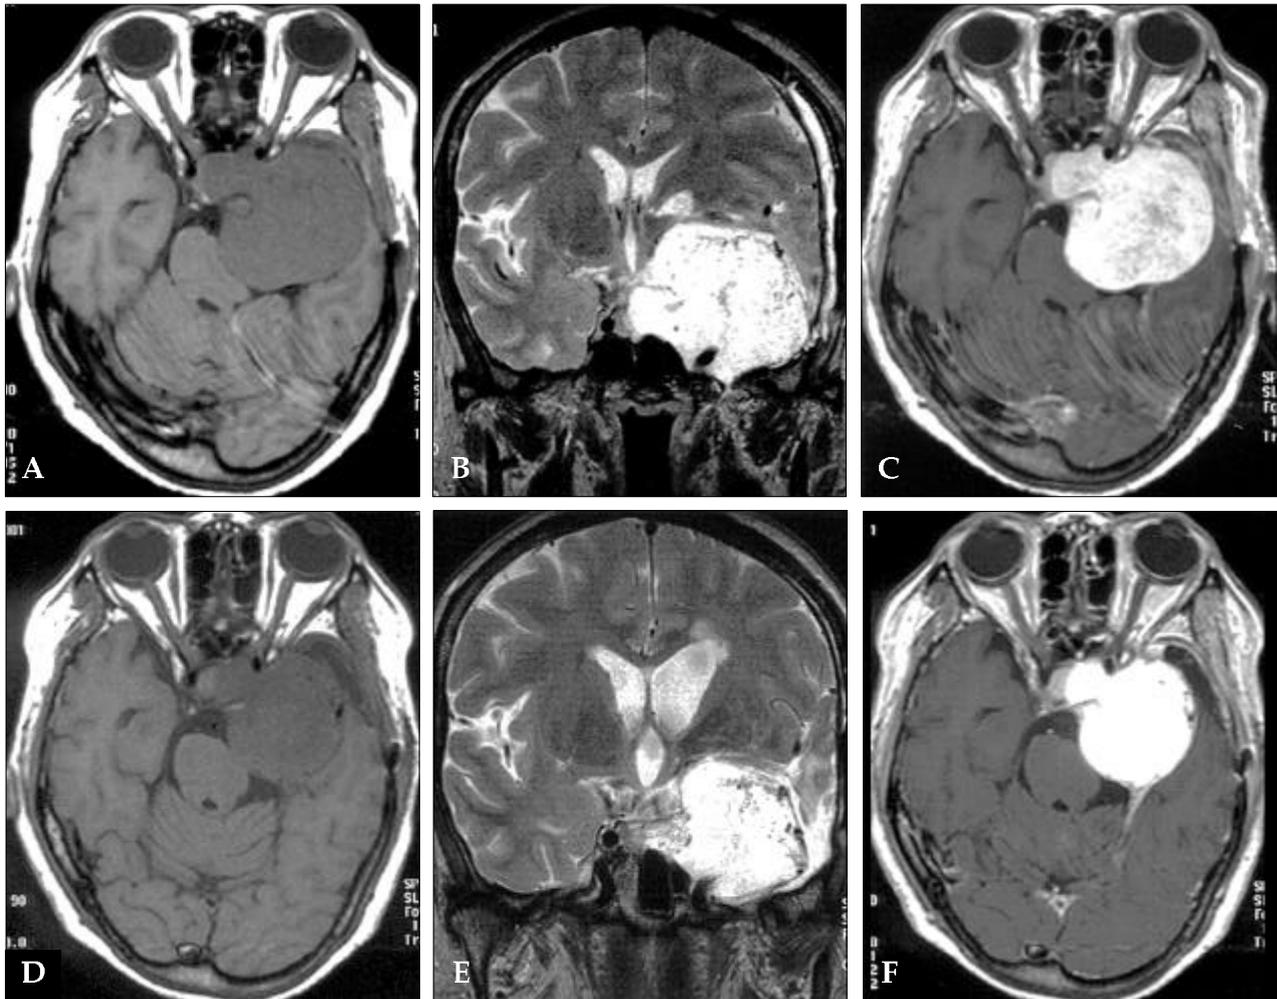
Before radiotherapy, a large cavernous hemangioma is noted in the left cavernous sinus compressing the left temporal lobe and pons A-C. A marked shrunken tumor is noted after irradiation D-F. (A-C) T1-weighted axial (TR/TE=600/14), T2-weighted coronal image (TR/TE/ Acquisition=3477/96/3 for TSE T2WI) and enhanced T1 axial images obtained before radiation show a relatively homogeneous low signal intensity on the T1 weighted image and a hyperintense signal intensity with some signal void structures within the tumor on the T2 weighted image. Dumbbell shaped tumor from the cavernous sinus to the left temporal area is noted encasing the left carotid artery. Homogeneous enhancement of the tumor is noted after an injection of Gd-DTPA. (D-F) After radiotherapy, a markedly shrunken cavernous hemangioma is noted showing a decompressed left temporal lobe and pons. All sequences were done using the same parameters as A-C. The signal intensities show no definite interval change, but after a Gd-DTPA injection, a denser enhancement can be seen.
